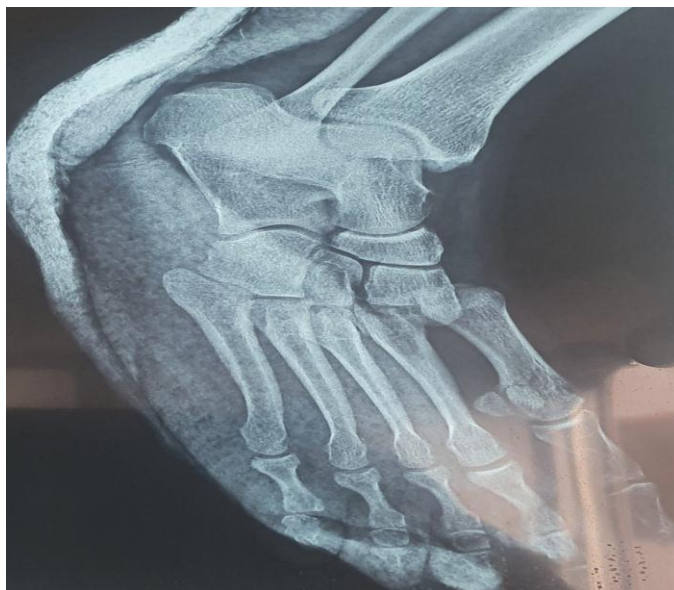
b: X-ray of the foot ¾ confirming the injury and the absence of other associated injuries.
